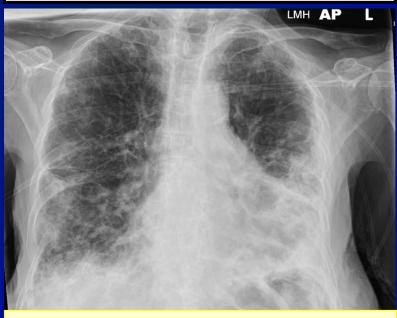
Chest X-ray during first admission
